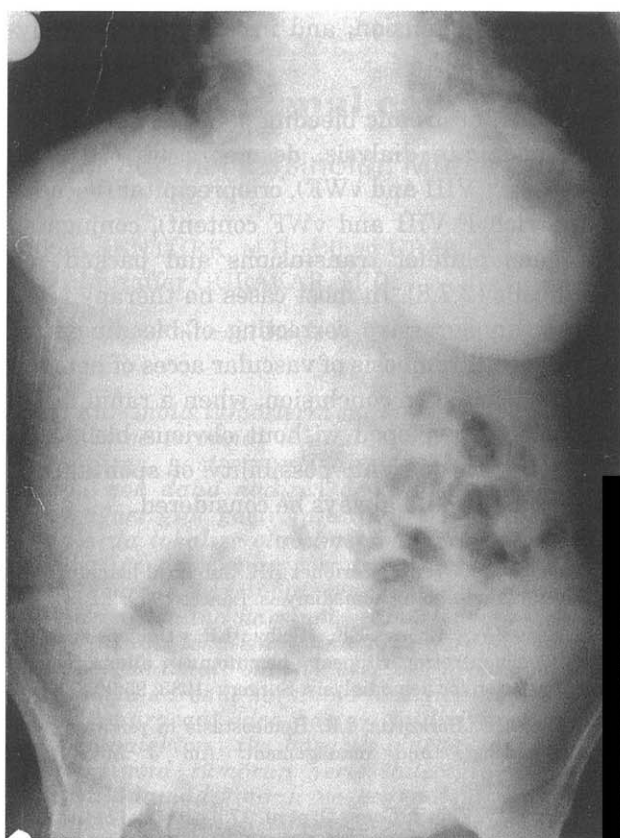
Abdominal X-ray sitting demonstrated a diffuse homogeneous opacity because of displacement of the colon gasses at the right side of the abdomen.
